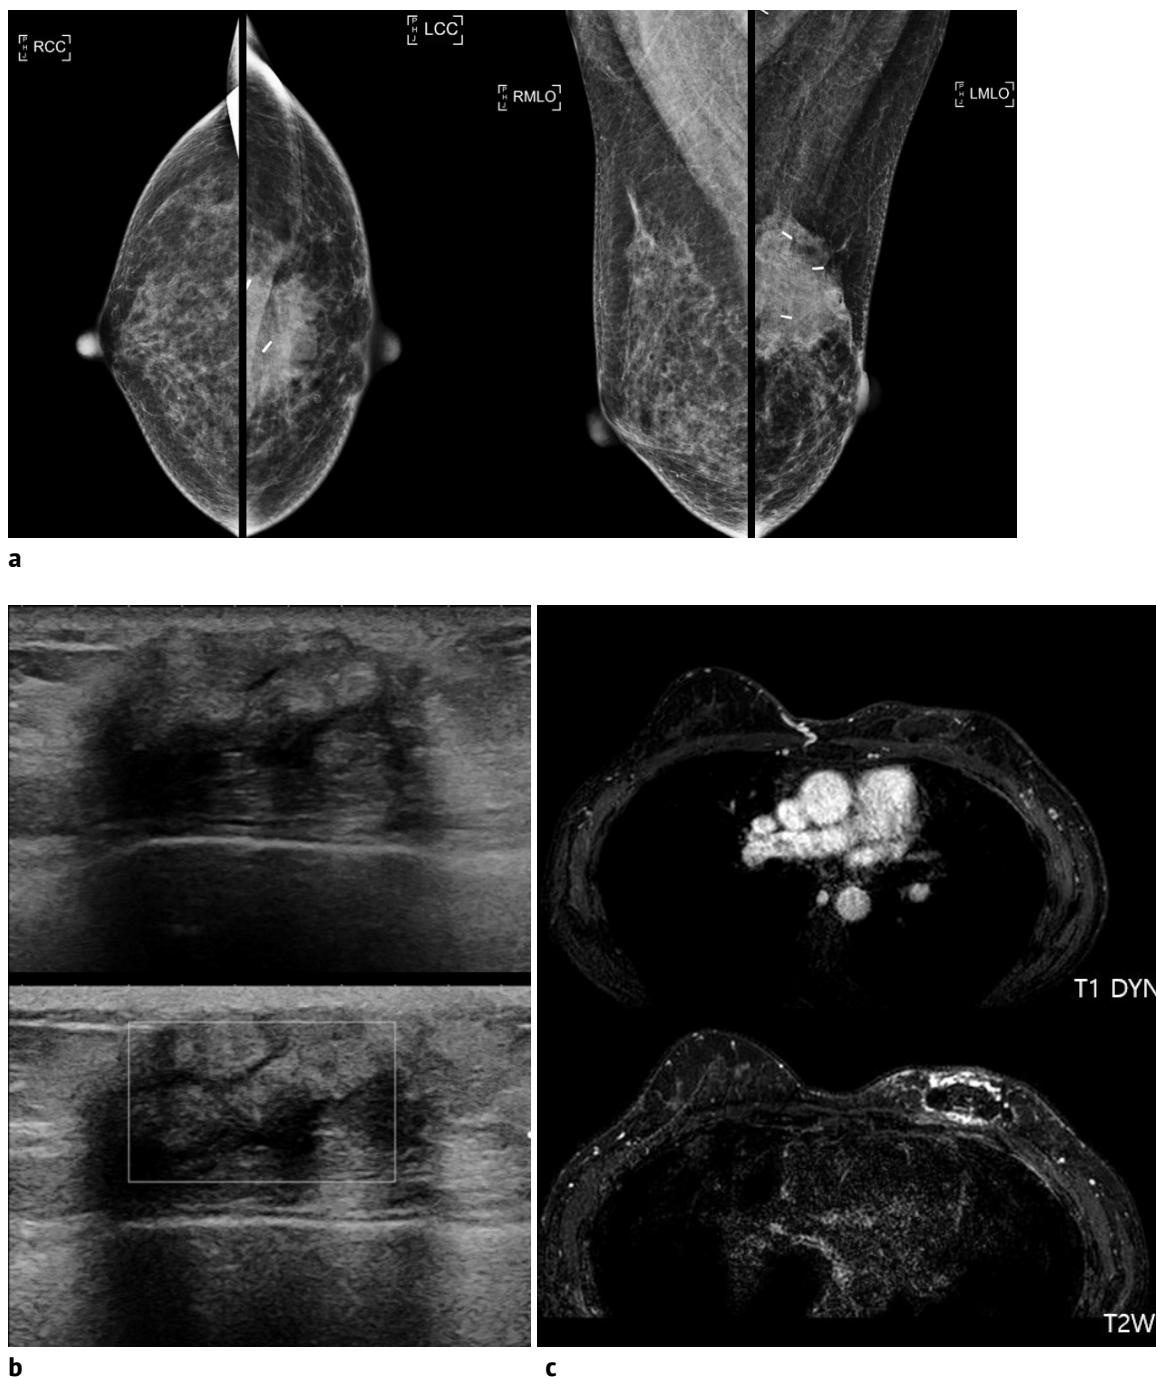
Postoperative surveillance images in a 47-year-old woman who had undergone left breast conserving surgery 6 months ago. (a) Mammography shows about 3 cm irregular high density mass with surgical materials at left upper breast. (b) Ultrasound shows artificial appearing 3.5 cm irregular heterogeneous mass with posterior shadowing. Partially it has angular margin and internal debris like echogenicity, but no internal vascularity. (c) Post operative 12 months breast MRI shows non-enhancing ADM with T2 low signal intensities, minimal fluid collection at the previous tumor resection site.
